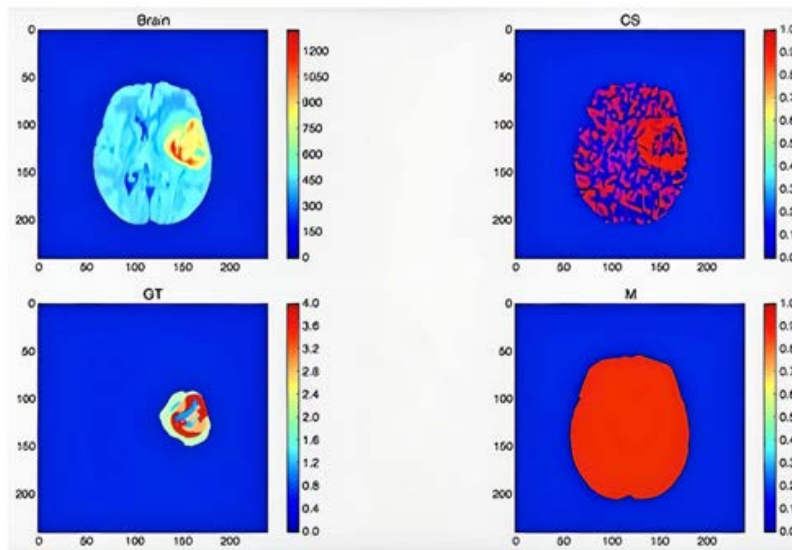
T1c-weighted MRI confidence surface
